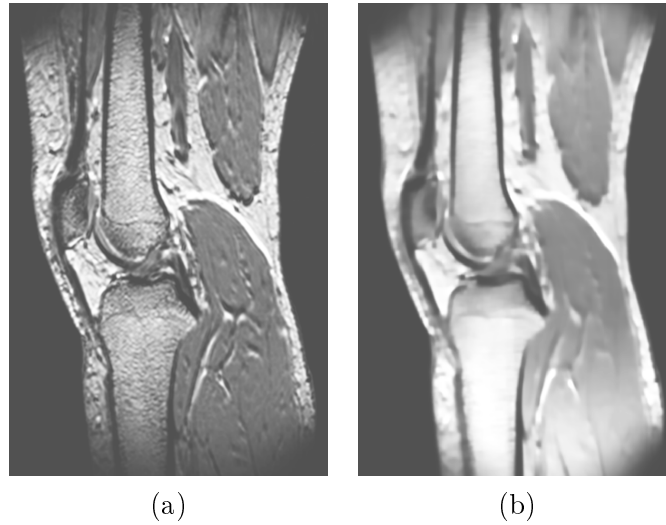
An MR image of the knee (a) before and (b) after anisotropic filtering.
